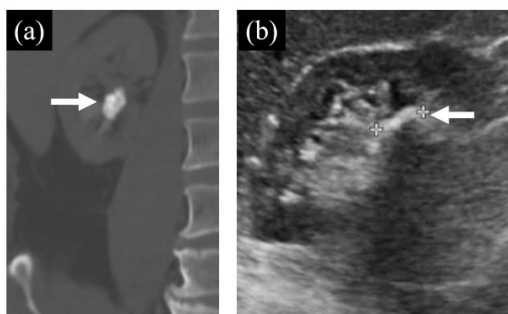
A 54-year-old man with failure ESWL outcome. A pre-operative imaging (a) showed an 18.8-mm right lower calyceal stone (arrow). A post-operative follow-up KUB ultrasound (b) showed a 13.5-mm stone at right lower calyx (arrow).
